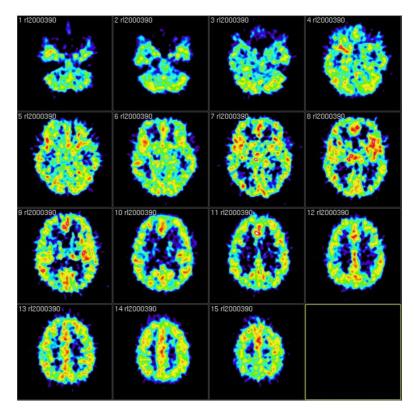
Axial view of a FDG-PET images.
